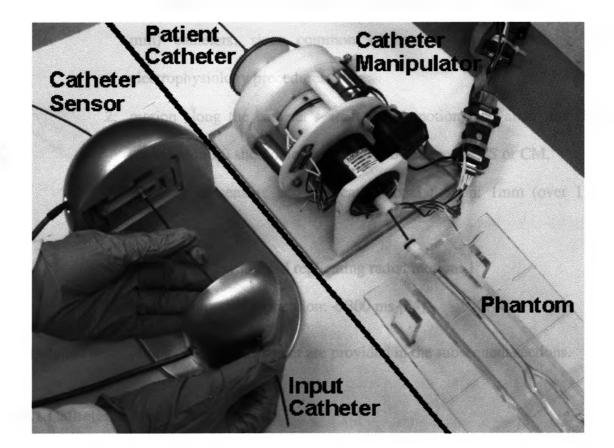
The remote catheter navigation system: The interventionalist can pull, push or twist the input catheter inside the catheter sensor. Motion measured by the catheter sensor is then replicated with the patient catheter using the remotely placed catheter manipulator. Image feedback is provided by a standard fluoroscopic x-ray system (not shown).
